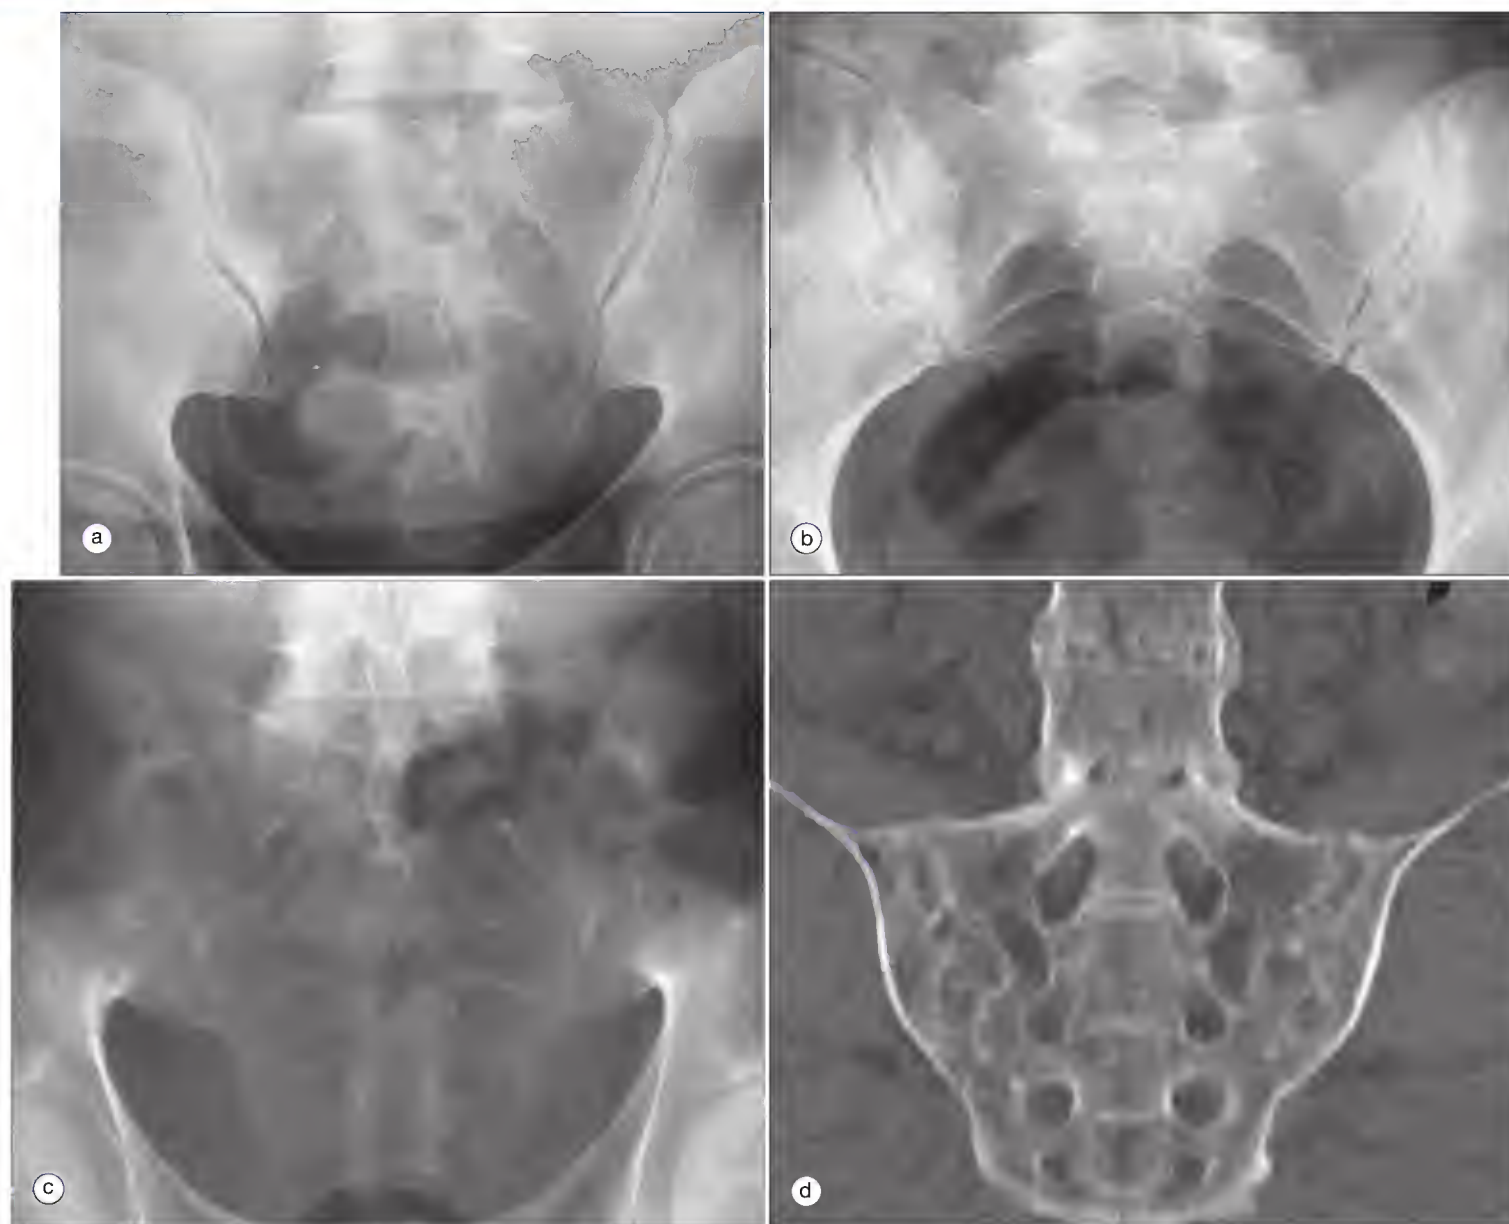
Ferguson view of the sacrum and sacroiliac (SI) joint evaluation. Better visualization of the anteroinferior SI joints is noted in the specialized Ferguson view (a) than in the standard AP view (b) of the sacrum in a normal patient. Ferguson view in a patient with ankylosing spondylitis (c) shows apparent complete fusion of bilateral SI joints. Coronal multiplanar reconstructed computed tomographic image of the SI joints in the same patient (d) better depicts near-complete fusion of the SI joints.
